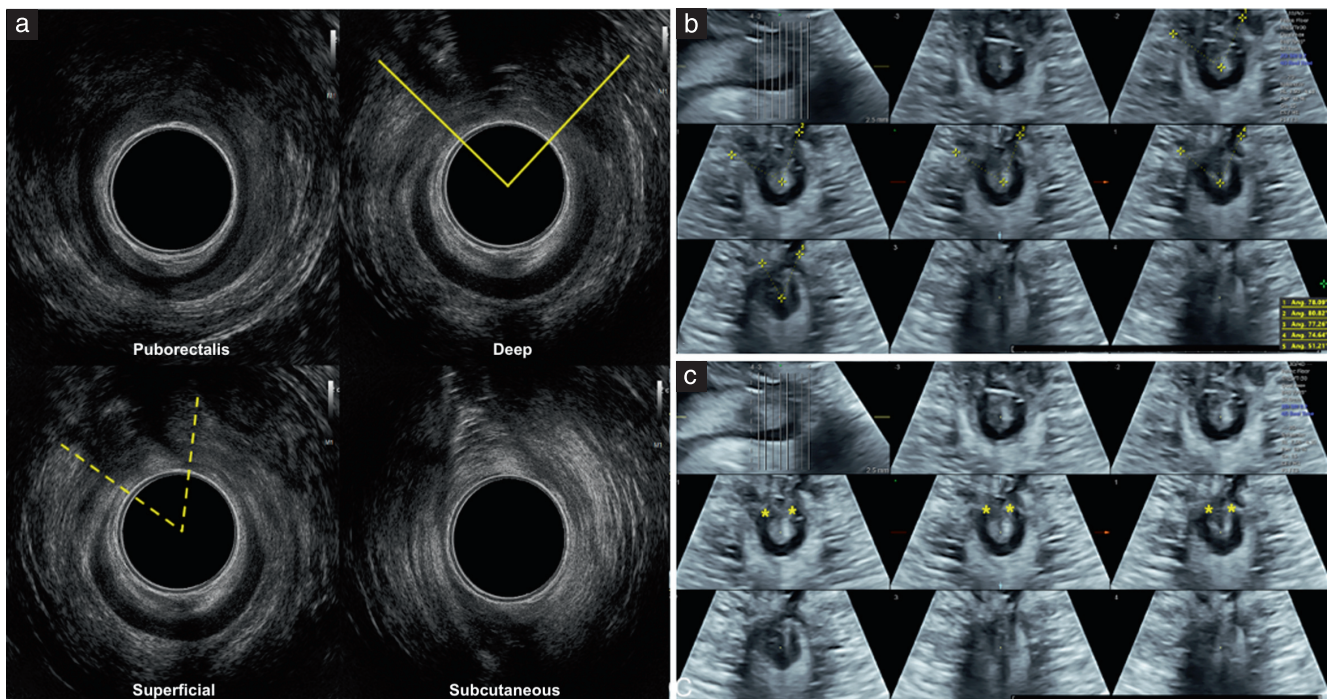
Endoanal ultrasound (a) and transperineal tomographic ultrasound (b,c) images obtained in the same patient at rest, showing measurement of external anal sphincter (EAS) and internal sphincter (IAS) defect using a three-point angle. (a) On endoanal ultrasound, EAS defect is indicated by solid-line angle and IAS defect by dashed-line angle. (b) On transperineal ultrasound, EAS defect is indicated by calipers in slices 2–6. (c) On transperineal ultrasound, IAS defect is indicated by stars in slices 3–5.
